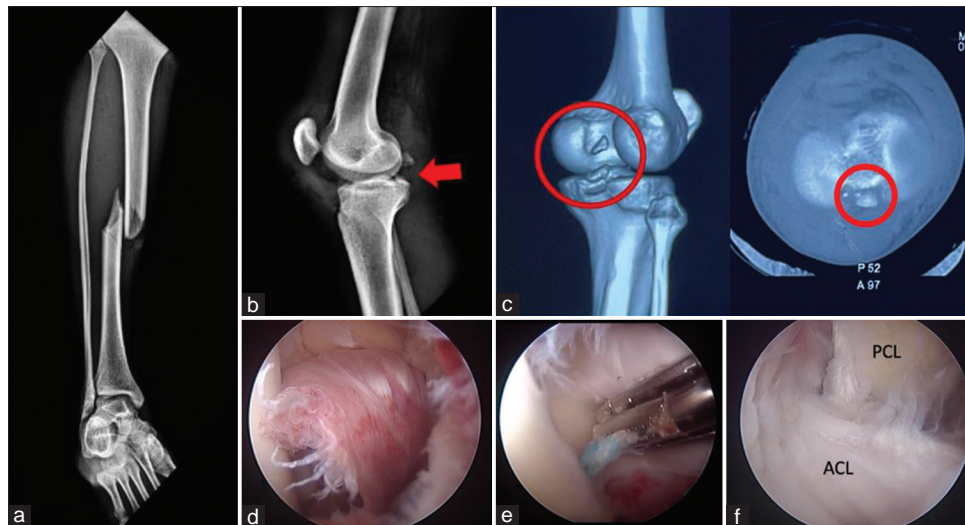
Case 2 (a) X-ray showing shaft of tibia fracture. (b) X-ray of knee showing PCL avulsion fracture indicated by red arrow. (c) CT images of PCL avulsion fracture indicated by red rounds. (d) Arthroscopic image of ACL soft tissue tibial avulsion. (e) Sutures taken on the ACL with knee scorpion. (f) Repaired ACL and PCL. ACL: Anterior cruciate ligament, PCL: Posterior cruciate ligament, CT: Computed tomography
